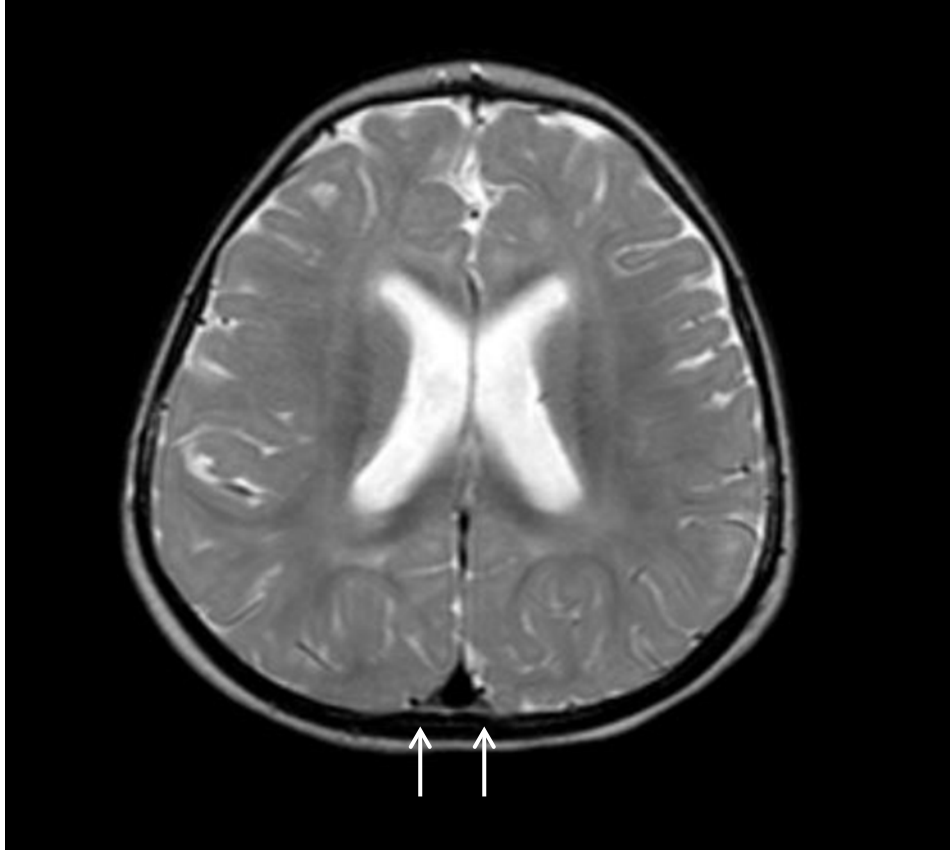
(A) MRI brain scan of III.6 at 2 years. The axial transverse weighted image (A) shows thinning of the posterior aspect of both cerebral hemispheres, as indicated by the double white arrowheads.
